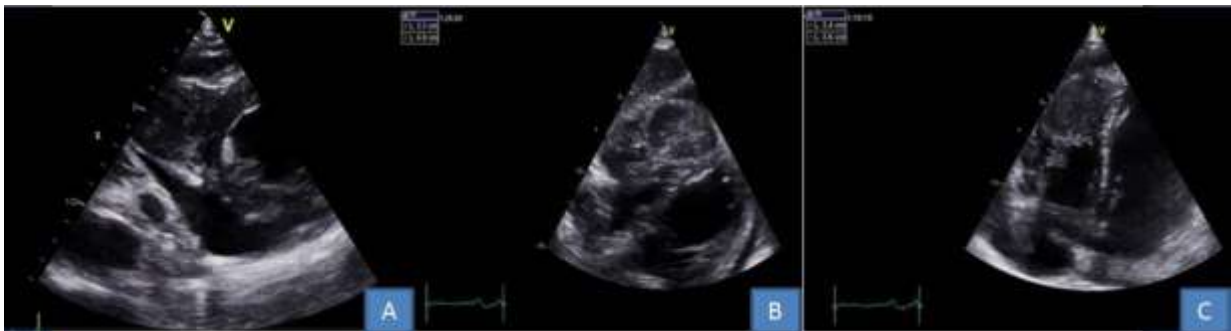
(TTE) echogenic mass measuring 34 x 36 mm, filling the apical portion of the right ventricle With a pericardial effusion, on a parasternal short-axis view (A), a subcostal view (B), and a four-chamber view (C).
